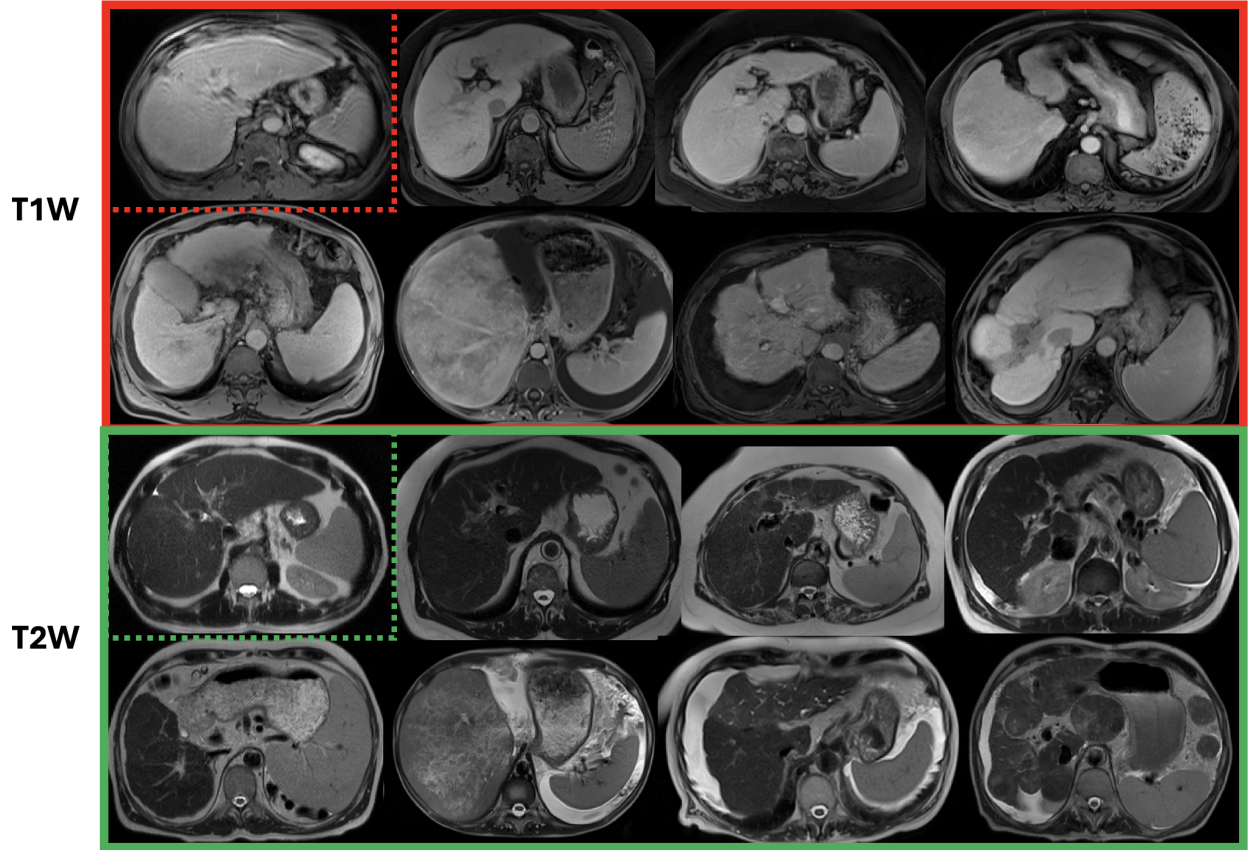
Different stages of fibrosis in liver MRI are shown in T1W and T2W samples, respectively. Varying levels of fibrotic tissues are observed across different scans, indicating the high variability and extreme challenge in texture and shape changes. To highlight the difference in fibrotic tissue diversity, MRI images in the dotted boxes (both red and green) are shown, they are having the smallest vulnerability to fibrotic tissue while still indicating cirrhosis. The first two rows are T1W, and the second two rows are T2W.
